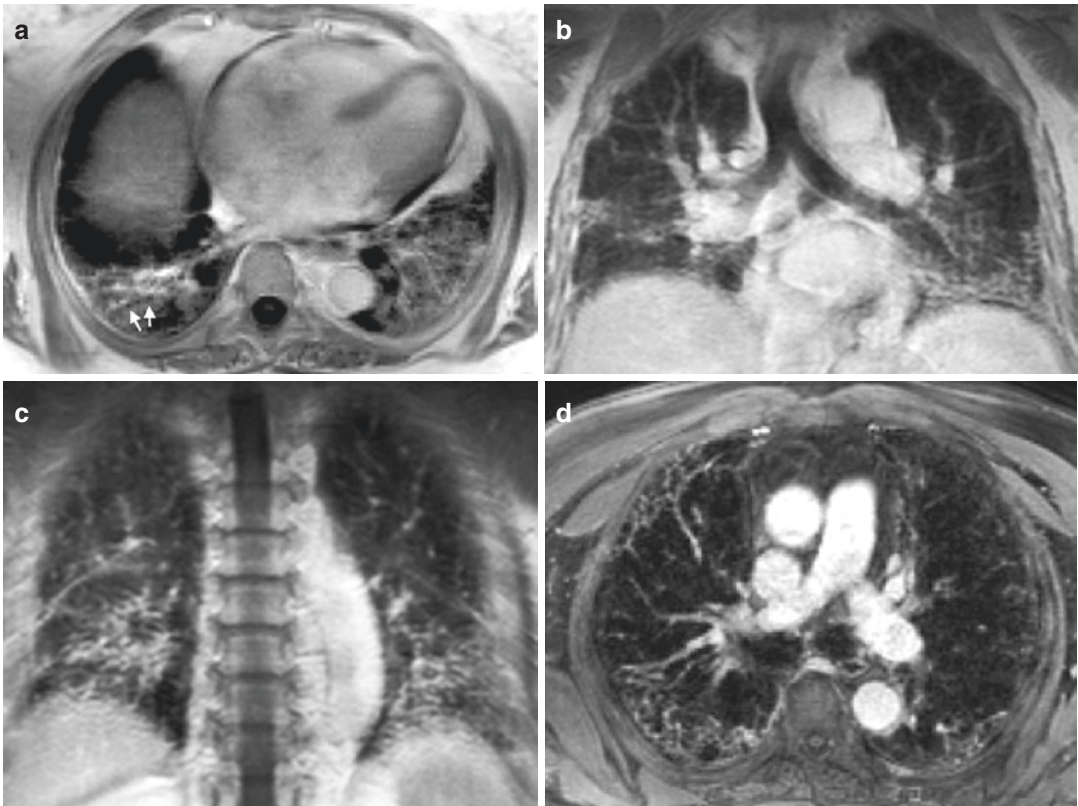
(a–d) A 74-year-old female patient with usual interstitial pneumonia associated with rheumatoid arthritis. (a) Post-contrast T1-weighted 3D FLASH axial image displays a reticular pattern with extensive traction bronchiectasis/bronchiolectasis (*arrowheads*). (b) Post-contrast T1-weighted 3D FLASH coronal image depicts typical basal and subpleural predominance of the findings.
